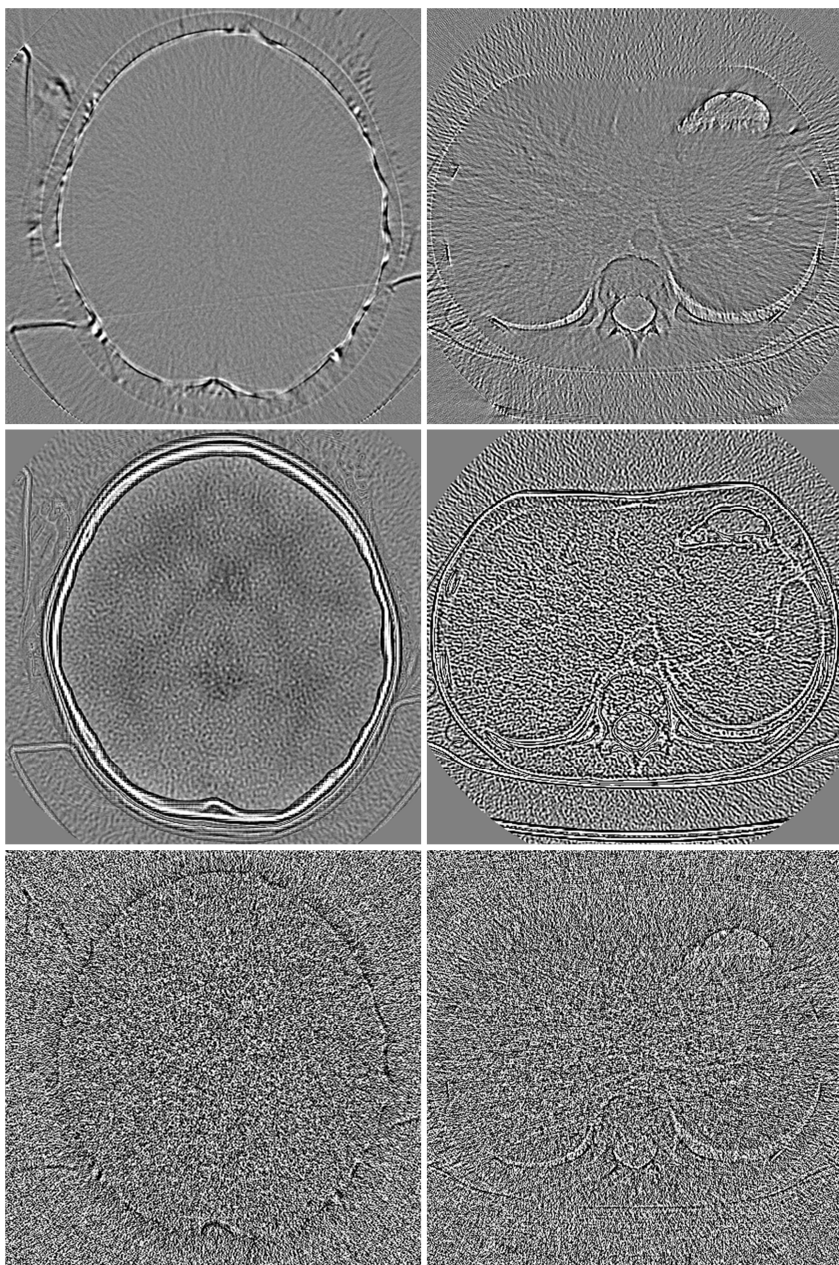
Shows a typical cerebral (left column) and a typical abdominal (right column) CT examination.  $NLD_{object}$  images (top row) show the distortion of the total variation algorithm, the difference images between ASiR 100% and FBP (middle row) show the difference between ASiR and FBP, difference images between the total variation algorithm and FBP with added noise (low dose; bottom row) show the noise to obscure the differences between the algorithms.
